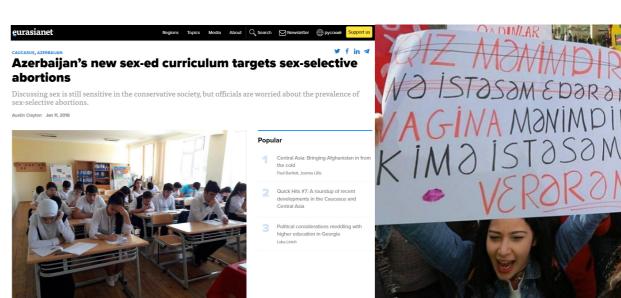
Sex Selective Abortions: This is a clear example of why it's important to stay sharp and critical of culture and tradition. Blindly following inherited norms over generations can lead to serious harm. What once led to large families in pursuit of a son has, with the introduction of ultrasound technology, turned into sex-selective abortion. Sex education can help build the critical thinking skills needed to recognize when tradition carries wisdom, and when it's time to form new ones.
